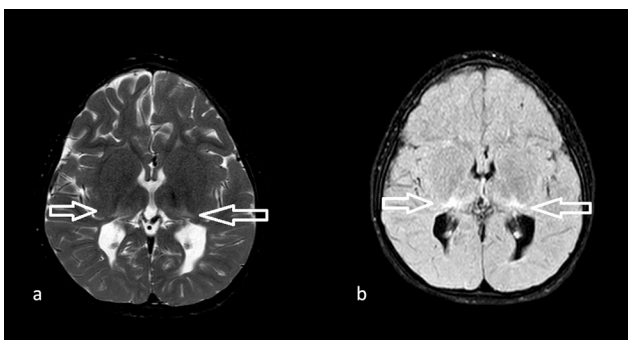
Thalamus L sign in a case of PVL: Abnormal signal increases in posterolateral extension in both thalamus on T2W (a) and FLAIR (b) MR images in the axial plane (arrows)
